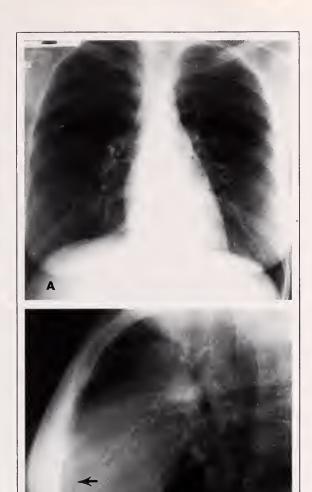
Small pericardial effusion secondary to viral pericarditis. On the PA chest radiograph (A) the cardiac silhouette is of normal size and shape. On the lateral view (B) there is a displaced epicardial fat pad sign with thickening of the anterior pericardial shadow to 4 to 5 mm (arrows) anterior to the epicardial fat pad. ECHO confirmed small pericardial effusion.
